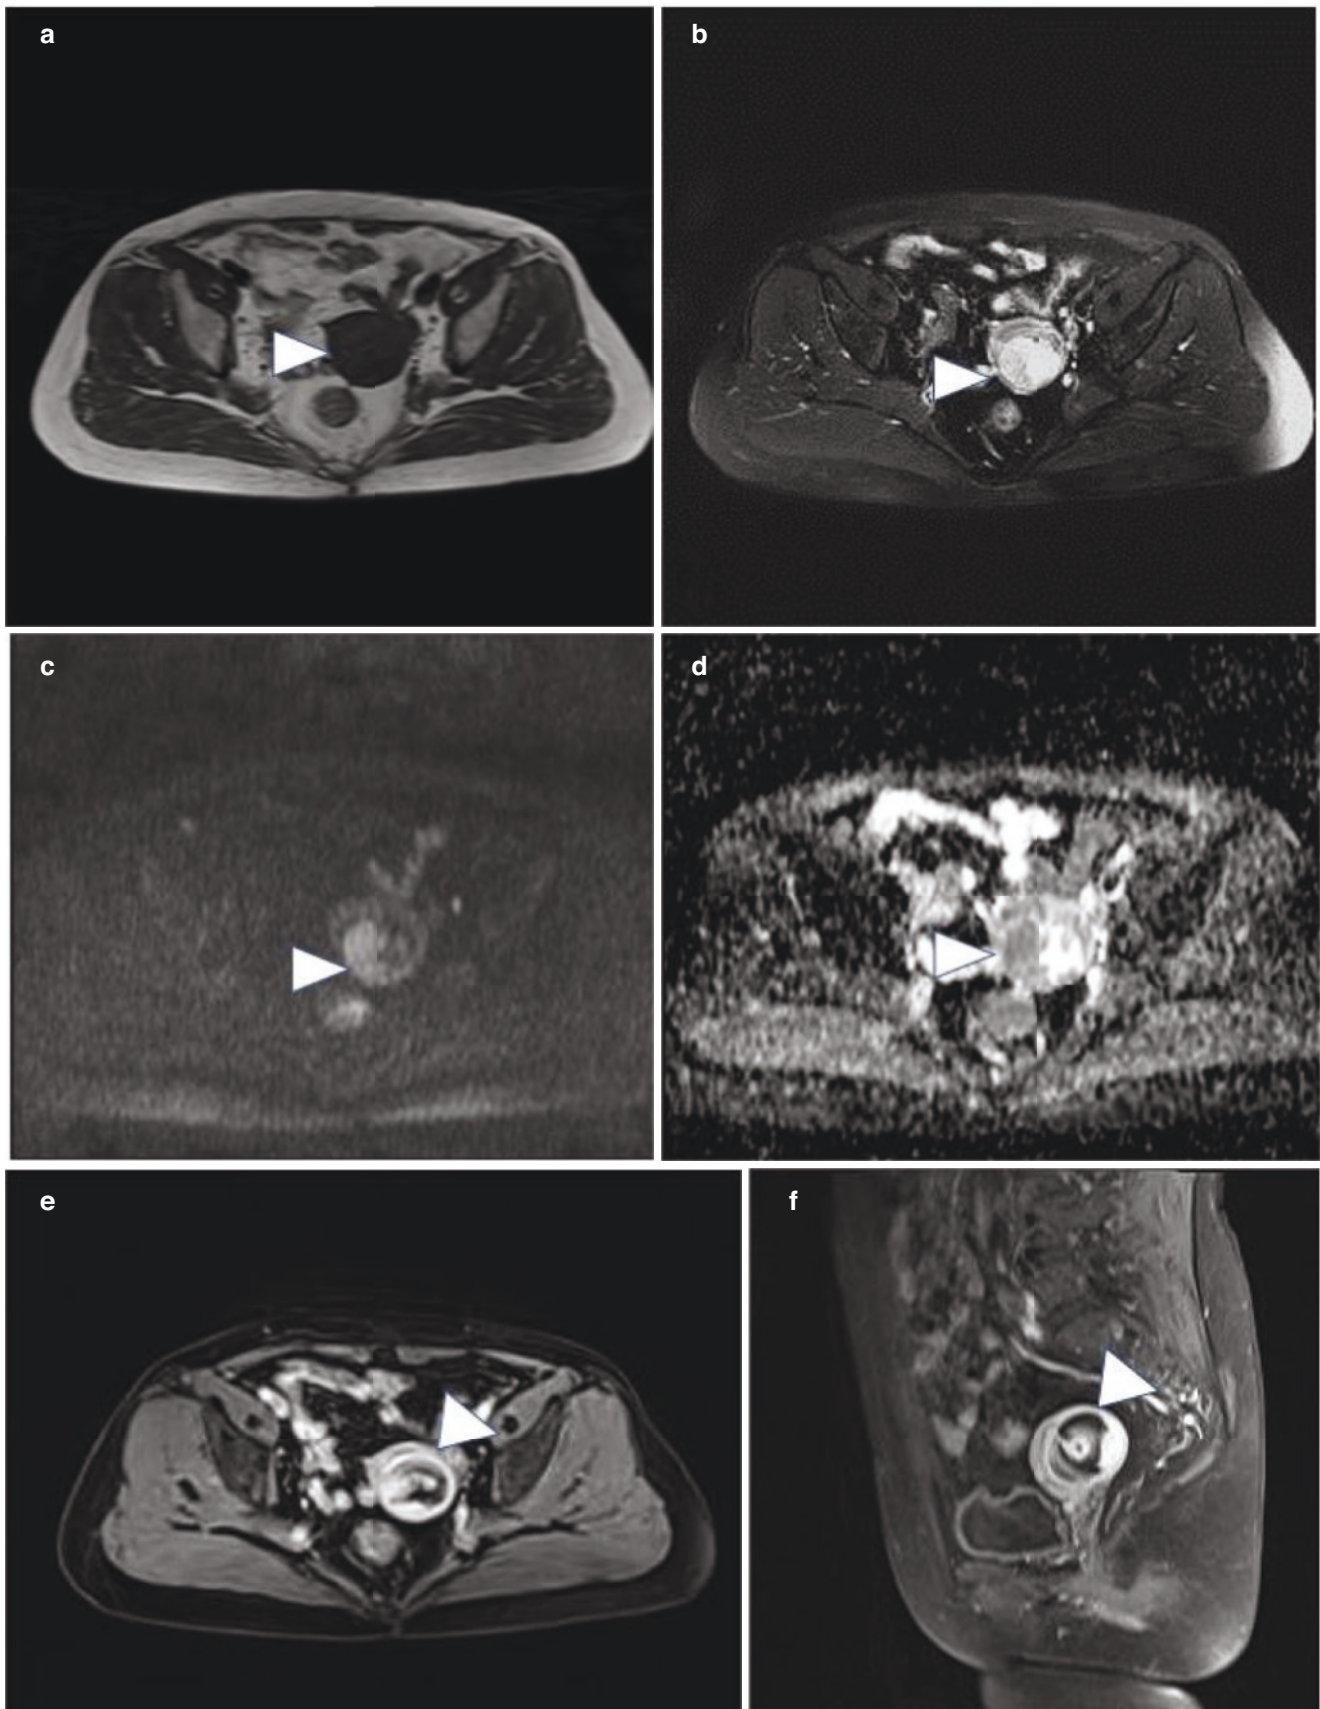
Case 1. ESS (low grade). On T1WI, the uterus (arrowhead) enlarged slightly with no obvious abnormal signal detected (a); on T2WI, a cystic mass was seen centrally in the uterus (b). The mass (arrowhead) showed restricted diffusion signal on DWI (c) and the corresponding ADC map (d). On contrast-enhanced images, the mass showed avid enhancement with intact uterine junctional zone (e, f)
